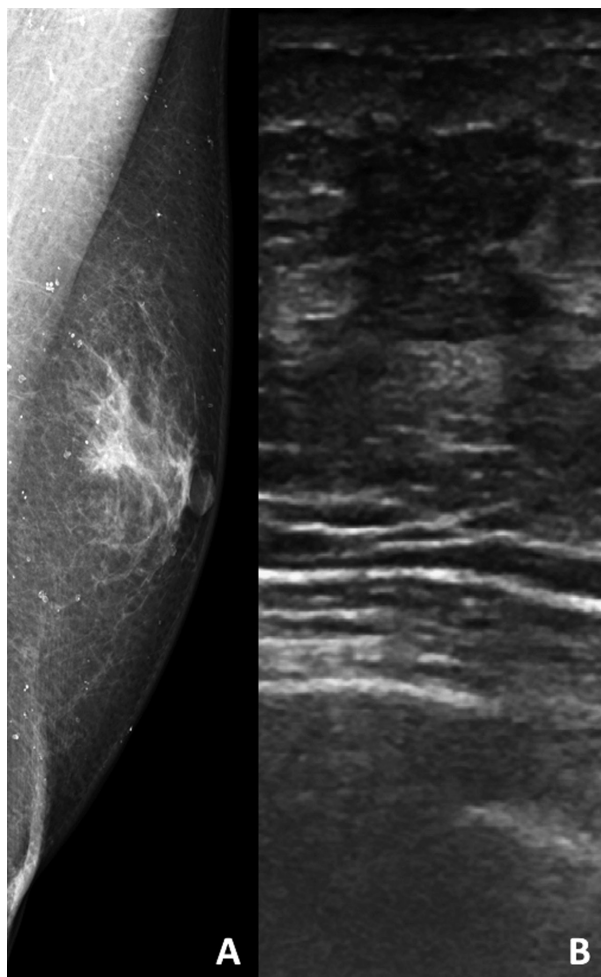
A) medio-lateral oblique mammogram shows the presence of true gynecomastia and a possible underlying mass; ultrasound evaluation B) reveals a subareolar hypoechoic nodule surrounded by echogenic fat
